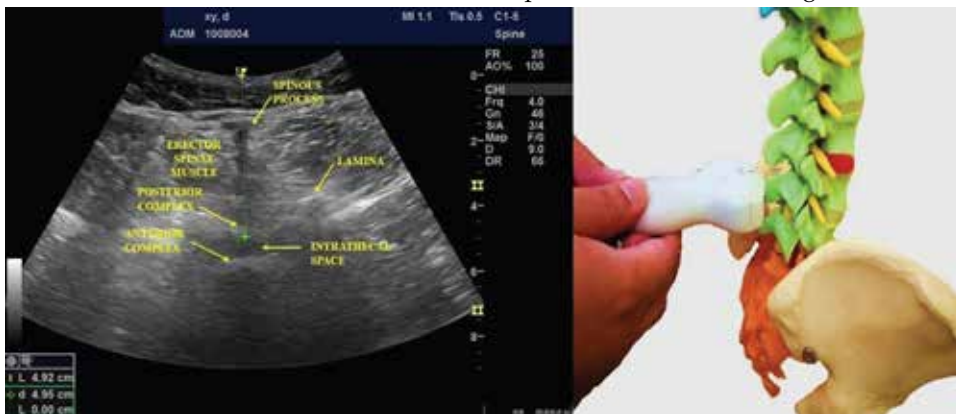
Ultrasound scan of transverse interlaminar view
